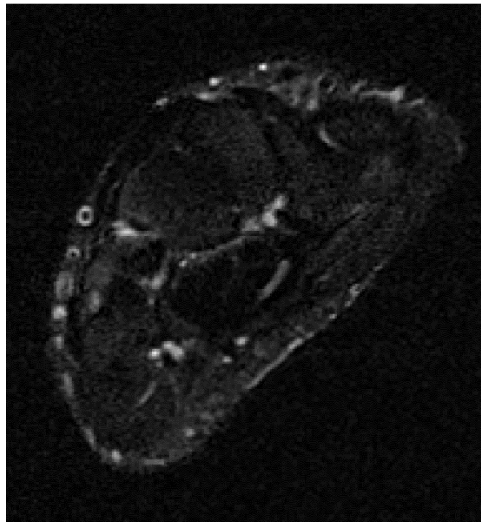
A MR image of the carpal tunnel used for testing the OT-MACH filter
